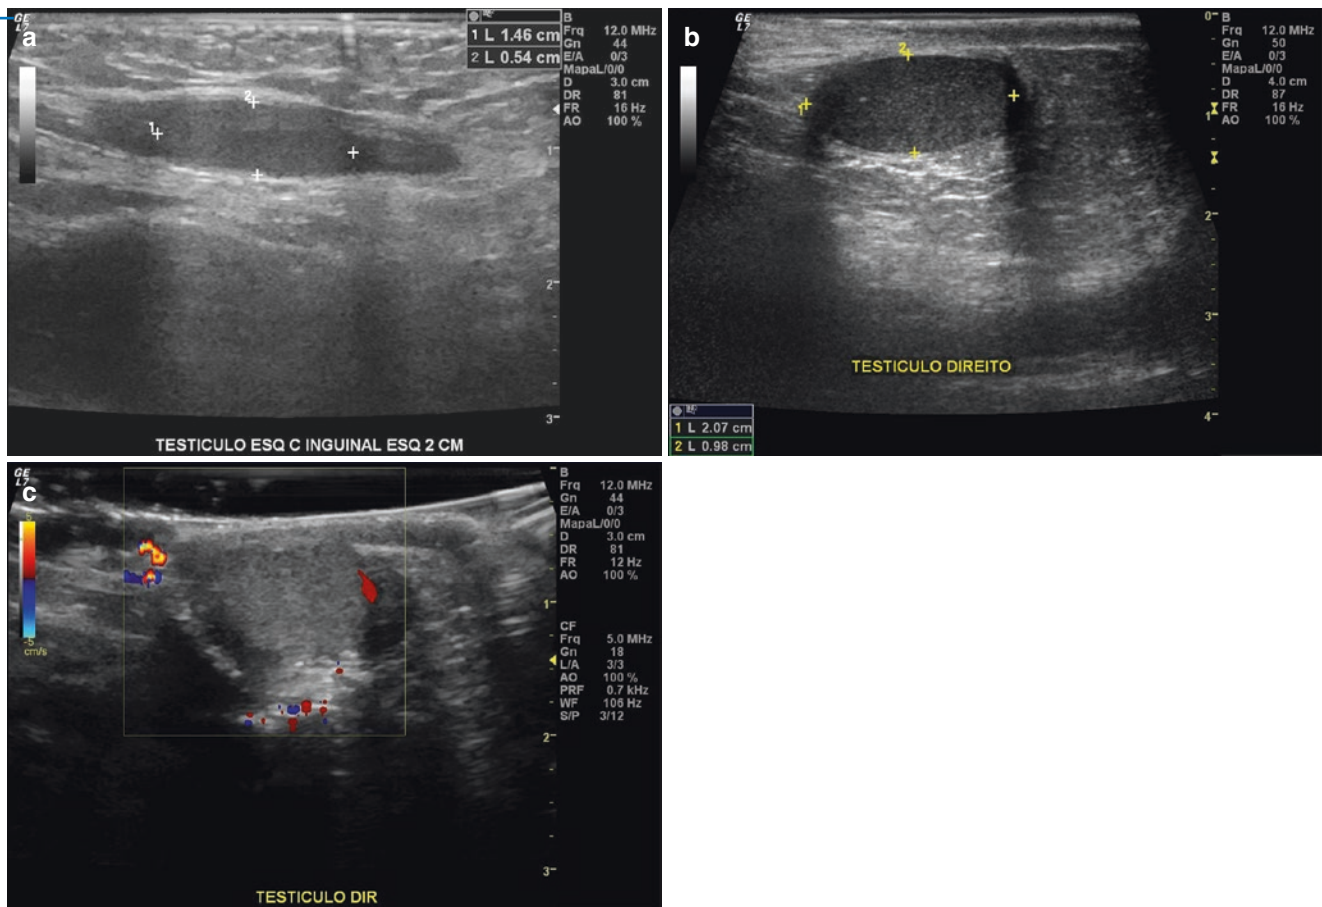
Cryptorchidism. (a) B mode ultrasound shows reduced testicle in the inguinal channel. (b) B mode ultrasound shows testicle in the inguinal channel. (c) Color Doppler ultrasound shows hypovascular testicle in the inguinal channel
